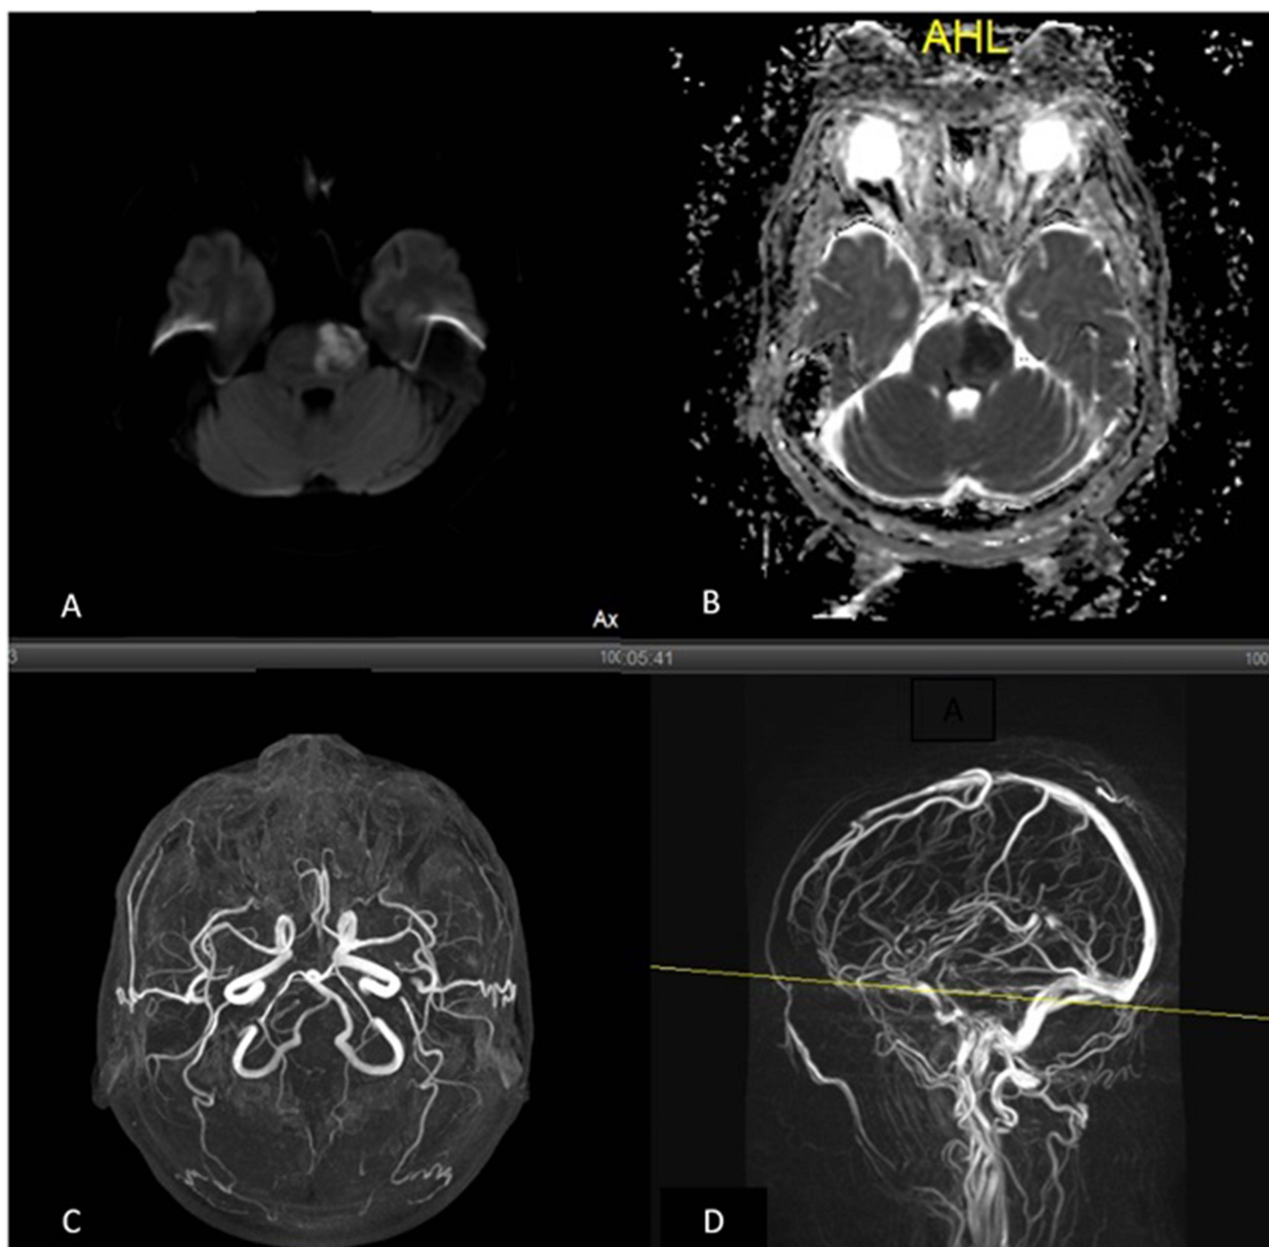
Similar patient from Figure 2, with a pontine lesion that appears hyperintense on DWI (A), confirmed to be a restricted diffusion area with a corresponding dark area on ADC map (B). There is no significant occlusion of the basilar artery on TOF-MRA (C) and no visible stenosis on TOF-MRV (D). This vascular information classifies the patient into small vessel disease stroke.
